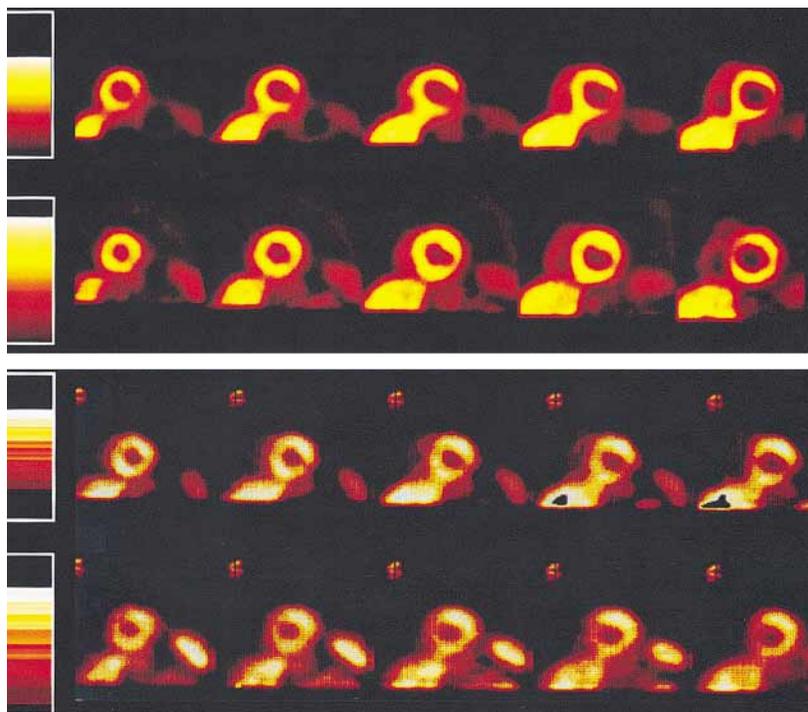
A patient with coronary angiographic evidence of occlusive (75%) stenosis in the proximal left circumflex artery with a reversible perfusion abnormality in the inferolateral on both Cu-62-PTSM PET and Tc-99m sestamibi SPECT is shown. Five short-axis images are shown from apex to base for stress/rest Cu-62-PTSM images (*top*) and stress/rest SPECT Tc-99m sestamibi images (*bottom*).
